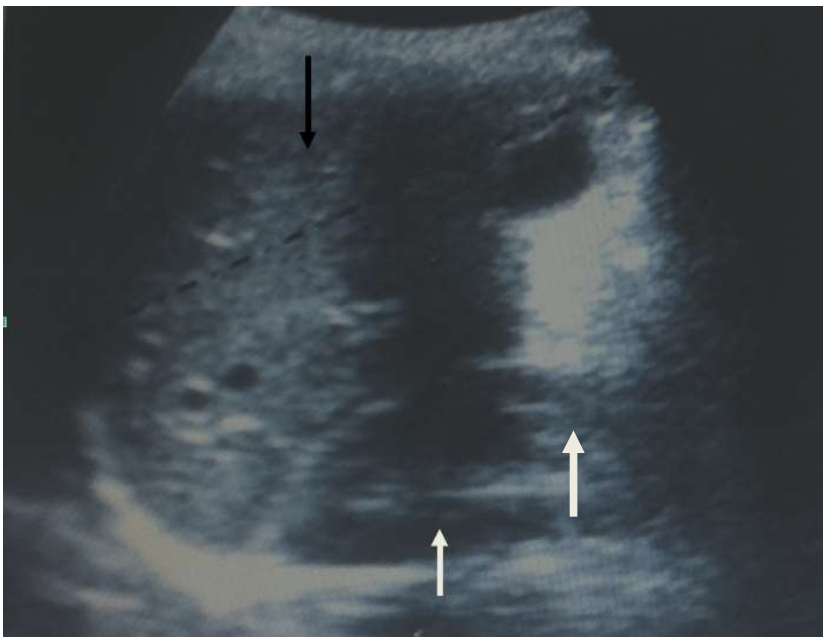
Sonogram showing longitudinal dimension of the liver at the midclavicular line (dashed arrow). Black arrow point to the liver, white arrow point to the right kidney. The hypoechoic bands across the liver were due to rib shadows.
